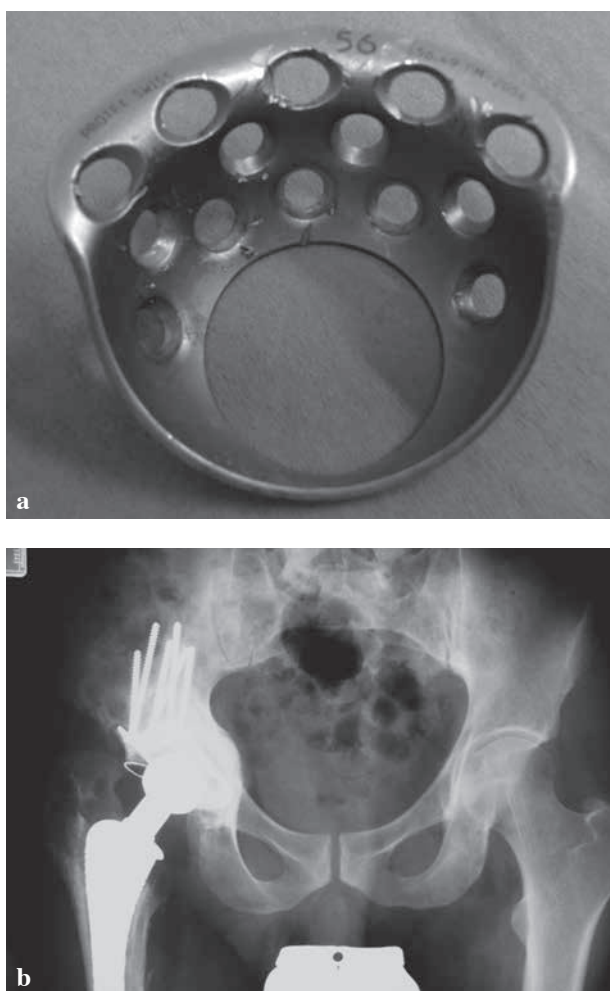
Müller acetabular reinforcement ring after explantation (a) and on postoperative radiograph (b).
